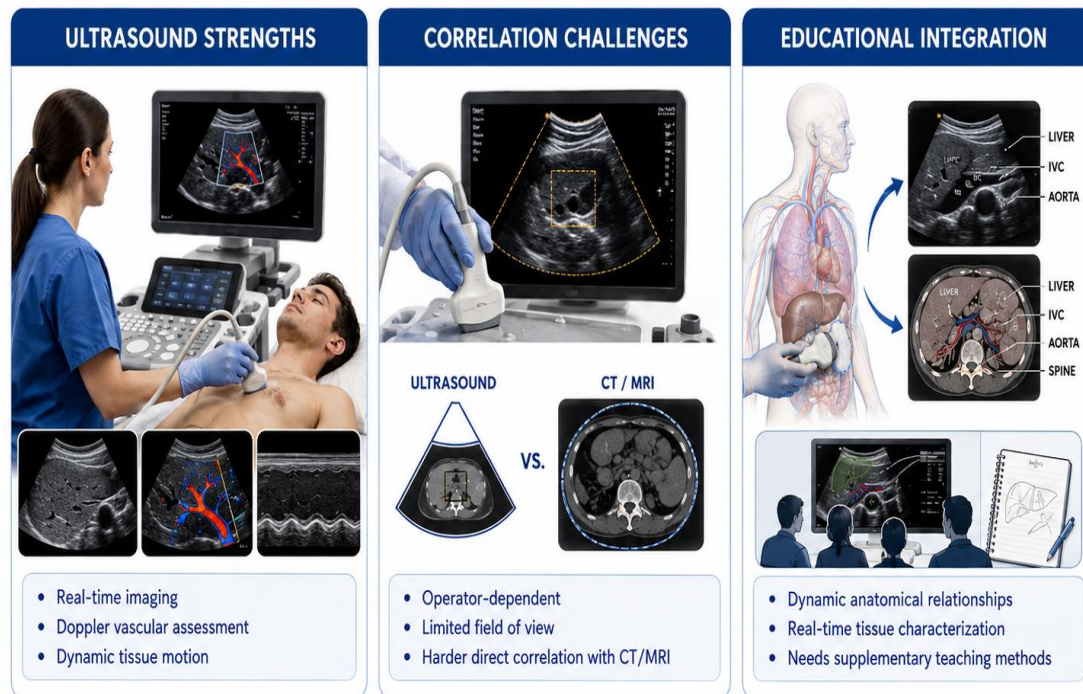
Ultrasound Correlation Methodologies
